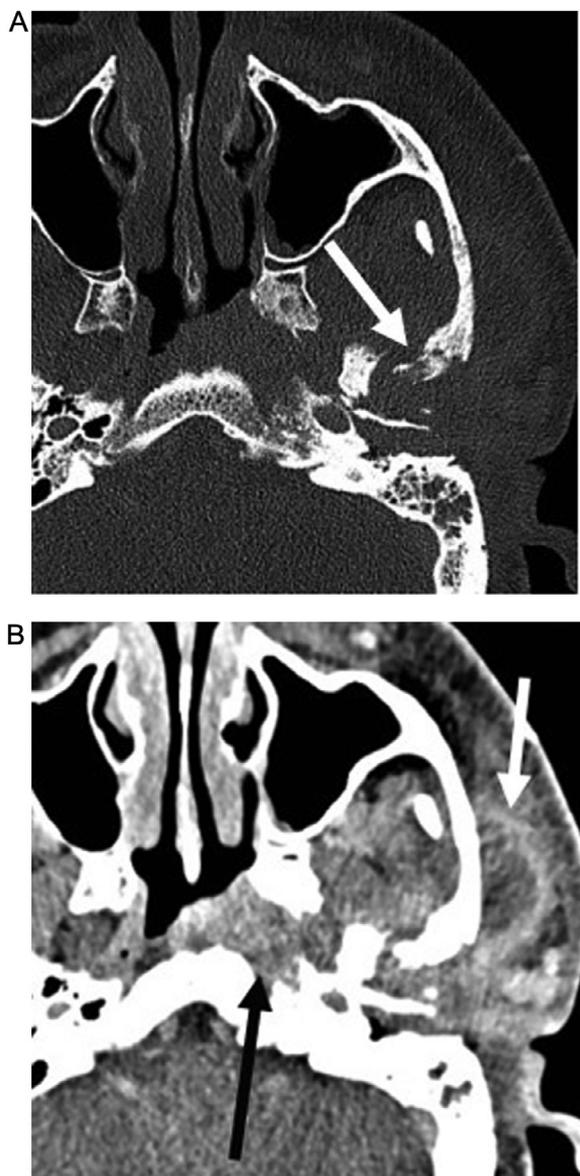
51 m h/o diabetes with pseudomonas infection. Axial CT (A) shows extension of NOE anteriorly with erosion of the TMJ including the mandibular condyle (arrow). Axial postcontrast CT (B) shows a masticator space abscess in the masseter muscle (white arrow) and also extension of infection to the nasopharynx (black arrow).
